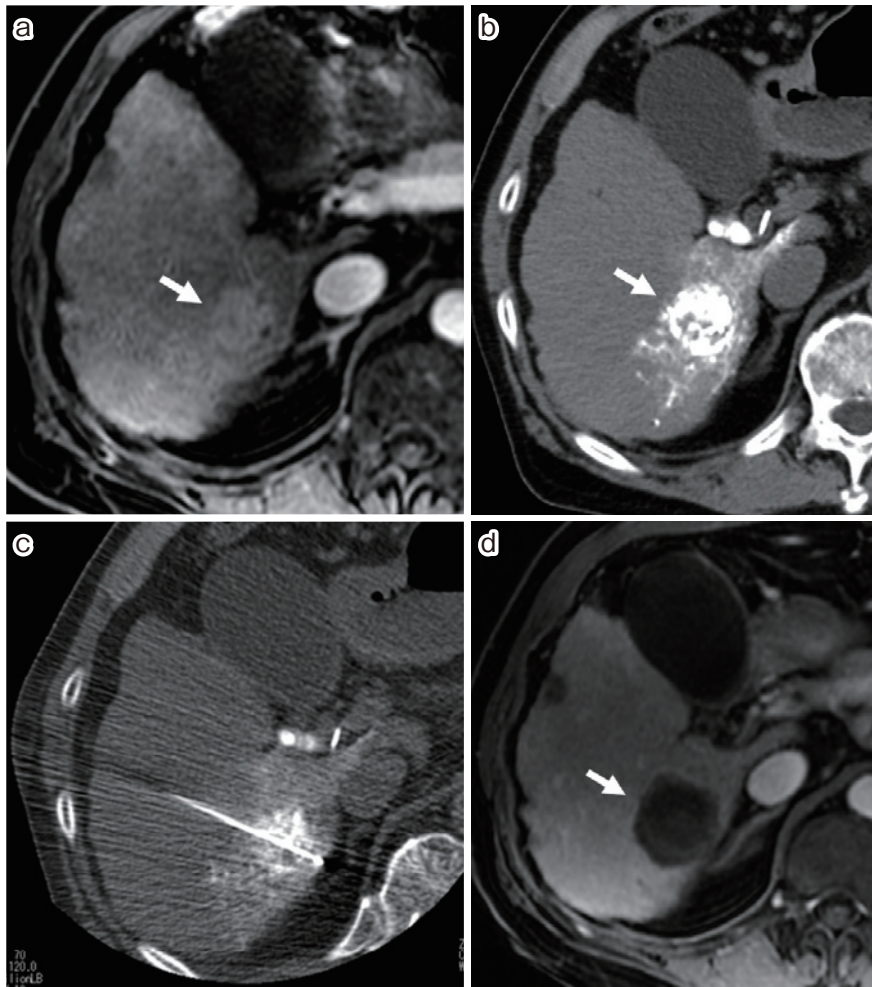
Case: Liver metastases from colorectal cancer after extended left hepatectomy. a, b) Magnetic resonance imaging (MRI) (hepatobiliary phase image) (a) and computed tomography during hepatic angiography (CTHA) (b) showing two liver metastases (arrows) in the right lobe. c) RFA under CT-fluoroscopic guidance was performed immediately after TACE using degradable starch microspheres mixed with mitomycin C. d) Contrast-enhanced CT showing adequate ablative margin (arrows) two days after RFA.
